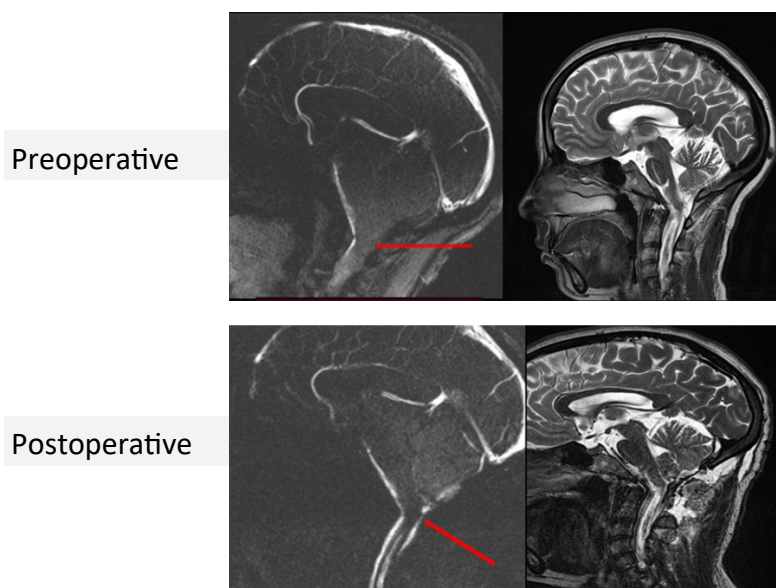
An MRI cine showing restoration of CSF flow at the foramen magnum (red arrow).
